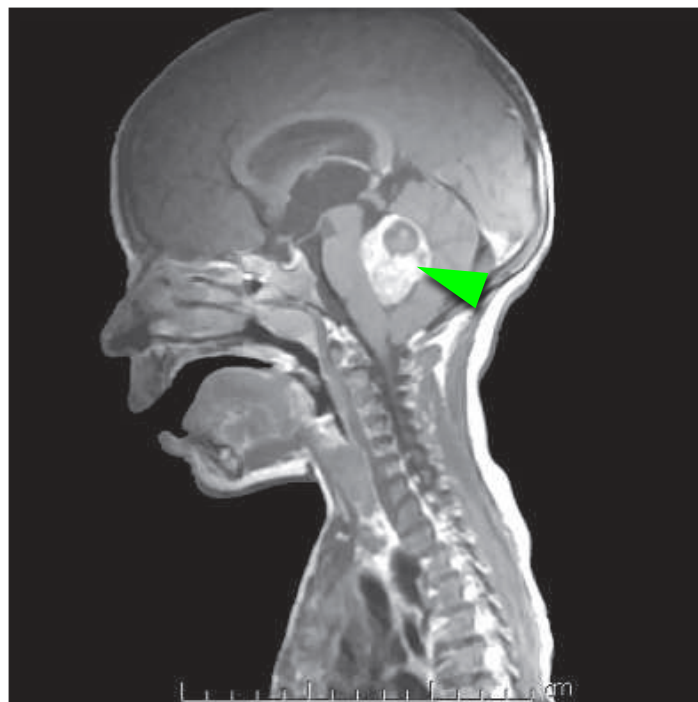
MRI scan of a 4-year-old child with medulloblastoma. The tumor mass, indicated by the green arrow, has invaded the fourth ventricle. (Image from (Polkinghorn *et al.* 2007))
